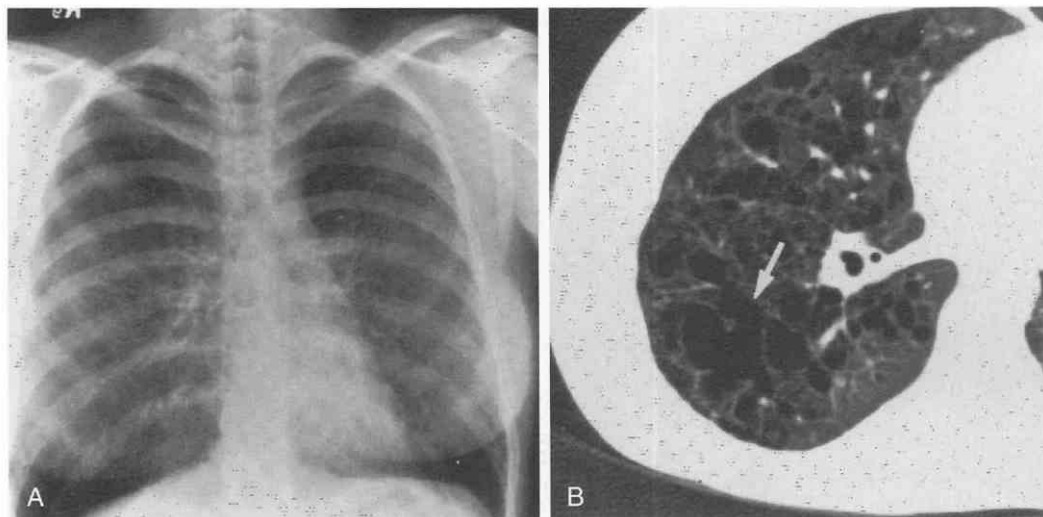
Advanced Langerhans' cell histiocytosis. A, Chest film in a 19-year-old woman with diabetes insipidus and dyspnea. A right pneumothorax and increased reticulations are present. B, High-resolution CT more clearly shows that the lung has been replaced by cystic spaces of varying sizes, some of which have coalesced into bizarre shapes (arrow). (From Kuhlman JE, Reyes BL, Hruban RH, et al: Abnormal air-filled spaces in the lung. *Radiographics* 13:47-75, 1993.)
